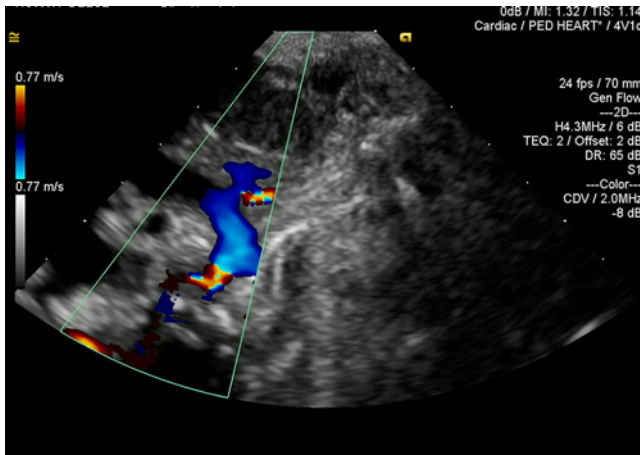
Coarctation of aorta in a patient with Williams syndrome prior to cardiac catheterisation as seen by echocardiogram. The residual coarctation was considered clinically significant, measuring 2.5 mm with a gradient across the coarctation site of 69 mmHg.
